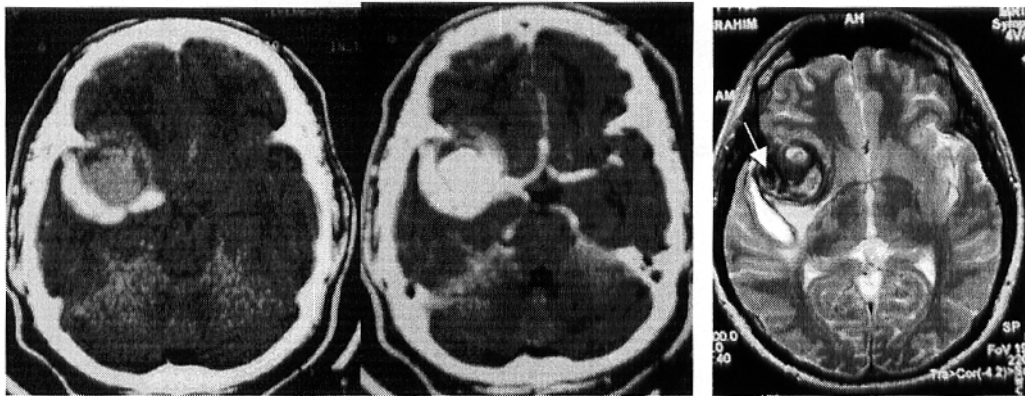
Pre and post contrast CT Brain showing the opacified patent slow flow lumen and thrombosed portion. Adjacent intraparenchymal haematoma noted at the posterior aspect. Signal void area (arrow) in T2W image depicts the patent residual lumen. Mixed signal intensities surrounding the lesion represented various stages of hematoma
